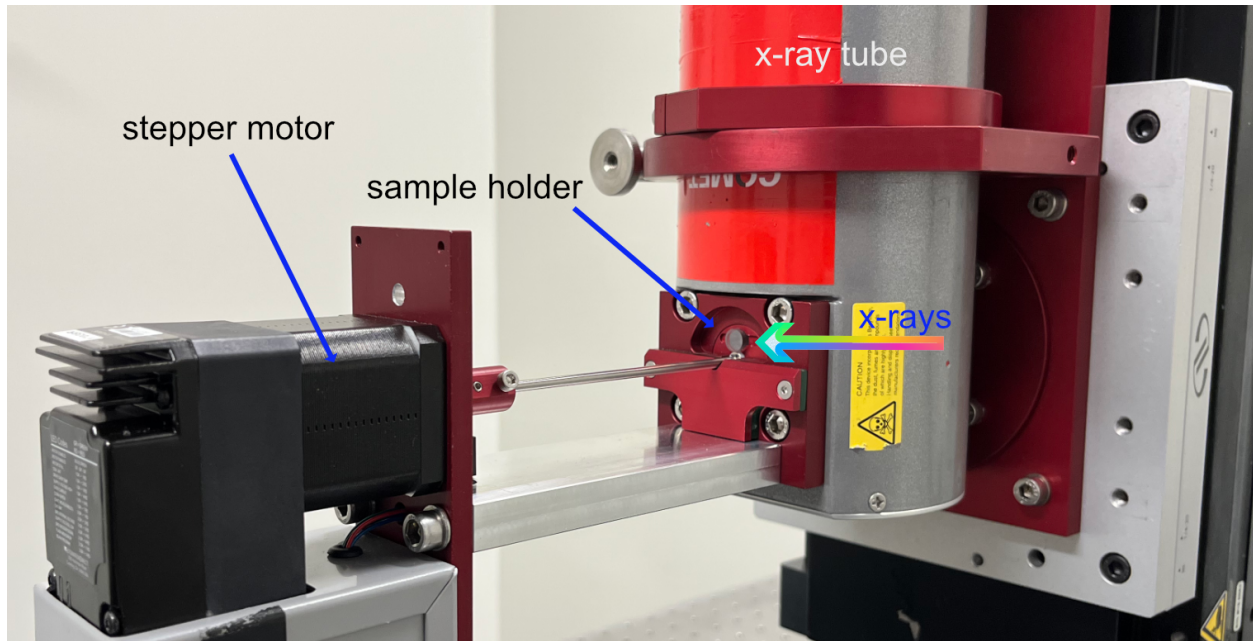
X-ray tube with shutter assembly attached. An acrylic cylinder used for immobilizing larvae is inserted into the sample holder.
